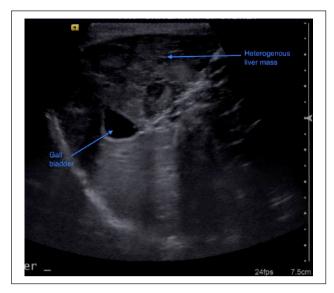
Ultrasound image of the heterogeneous liver mass with poorly demarcated borders producing a moderate mass effect over the gall bladder
